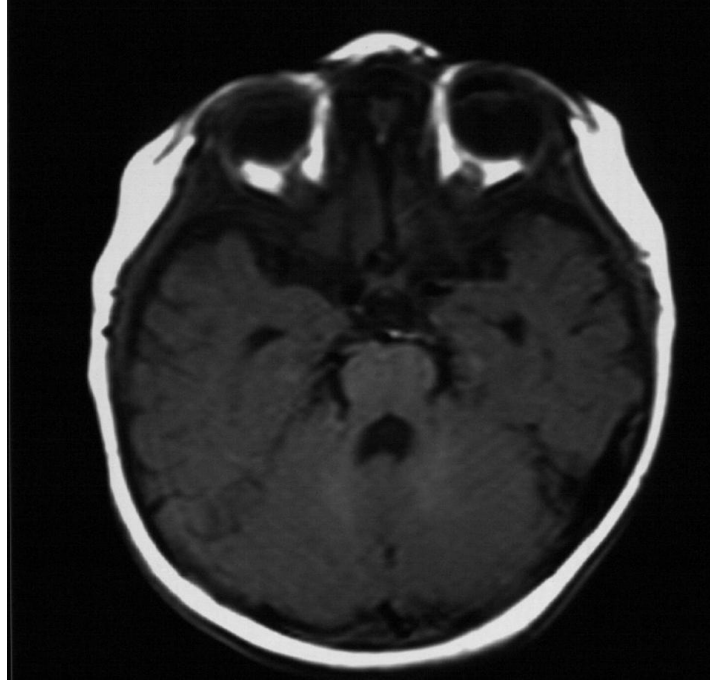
“Molar tooth” sign at cranial MRI (axial plane).
